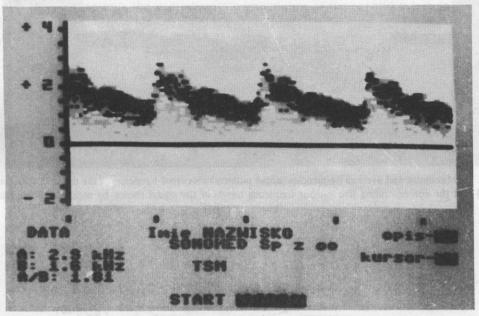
Blood velocity measurements in the middle brain artery in terms of time carried out by means of the transcranial Doppler device IPPT PAN-Sonomed, Warsaw
